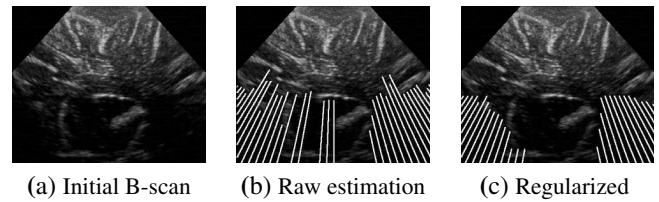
Example of shadow estimation on intraoperative brain ultrasound images. For legibility, only a few lines were sampled in this case. On the input B-scan (a), results of the shadow estimation are given without regularization (b) and after regularization (c). The regularization removes outliers and smooths the profile of the shadow boundaries.
